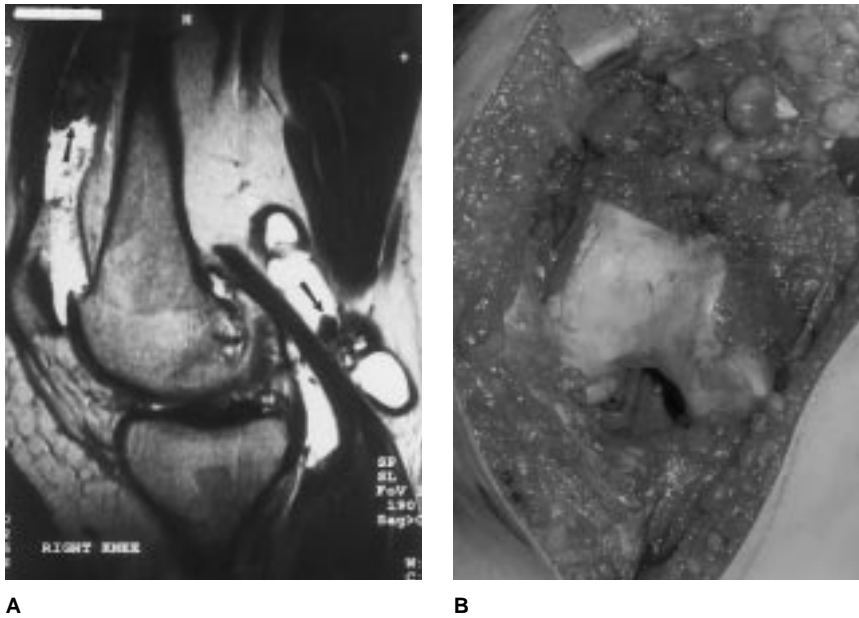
A, T2-weighted sagittal MR image of a 26-year-old woman with recurrent hemarthroses and painful limited range of motion in the knee. Image shows multiple low-signal densities throughout the knee, most prominent in the suprapatellar pouch (arrow at left) and the associated popliteal cyst (arrow at right). B, At open synovectomy, the gross appearance was characteristic of pigmented villonodular synovitis.
